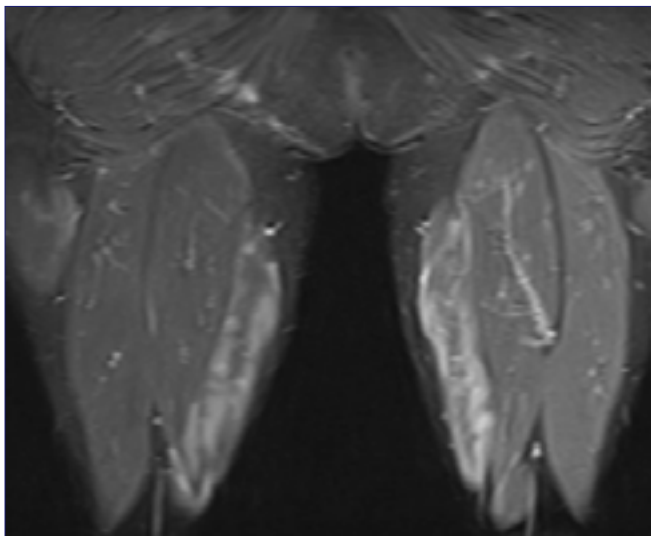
MRI STIR sequences revealing patchy high signal within the semimembranosus muscles indicating inflammation.
